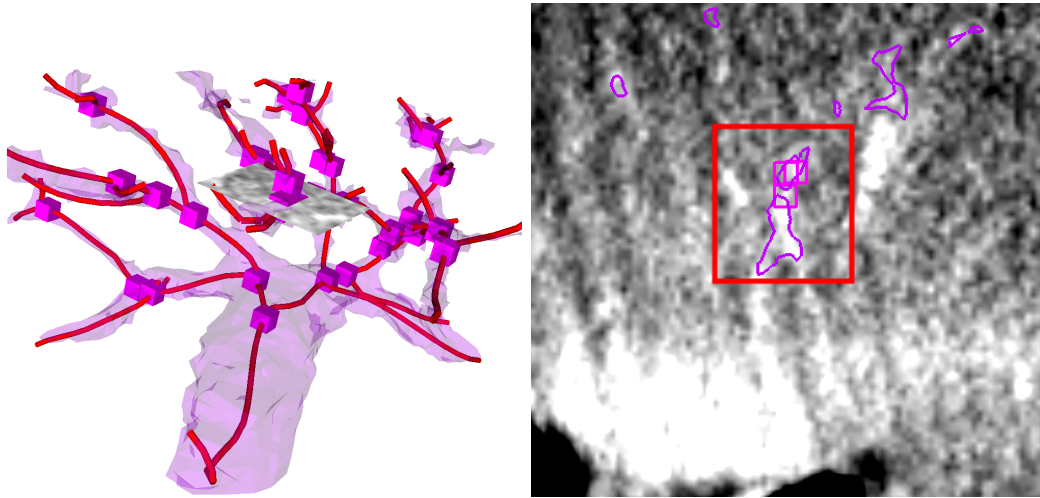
8: The CBCT image, from session PB, has low contrast and is noisy. The segmented PV has mostly thick principal vessels. On the ellipse, a large disconnected branch is missing from the segmentation.
